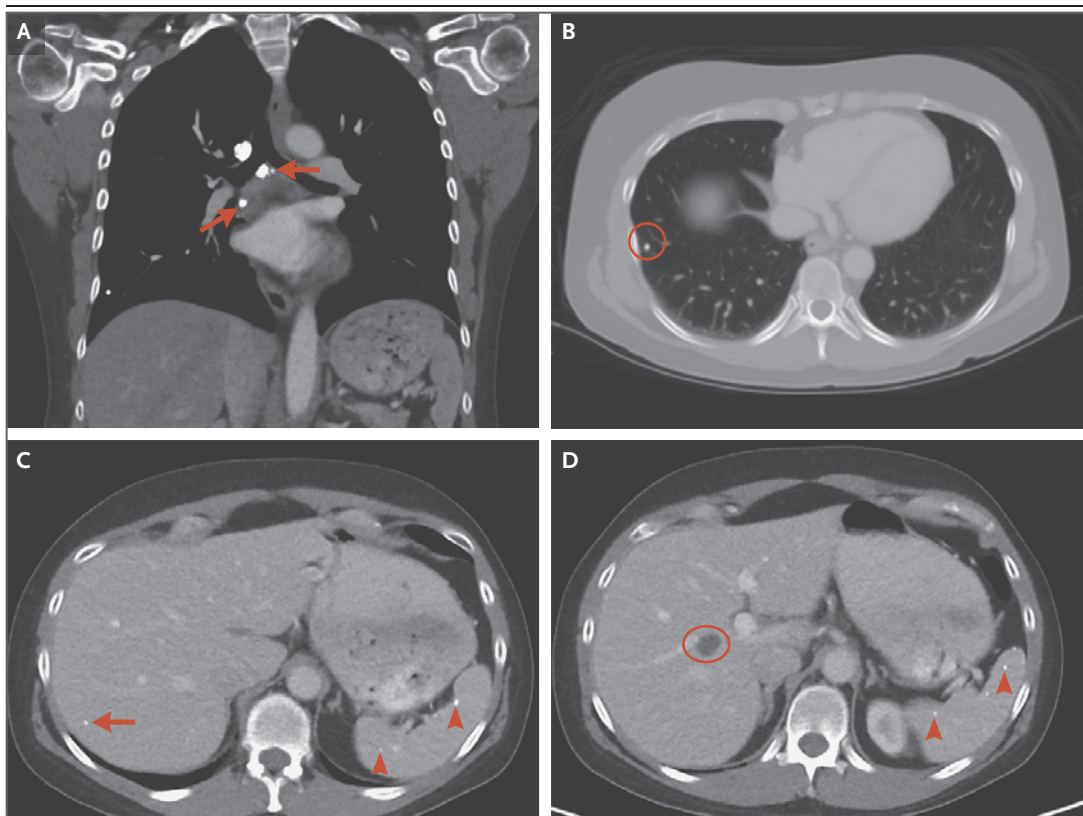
CT of the Chest and Abdomen.
